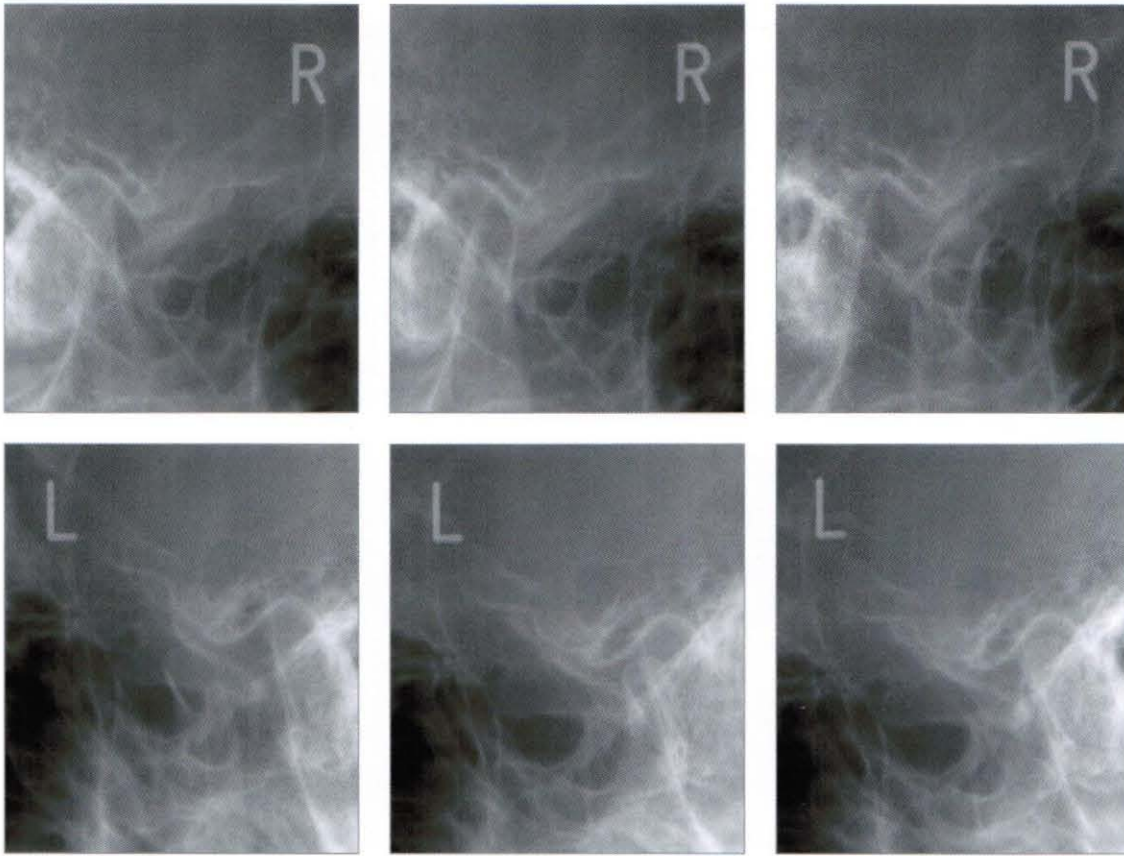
Pre-treatment transcranial radiograph
